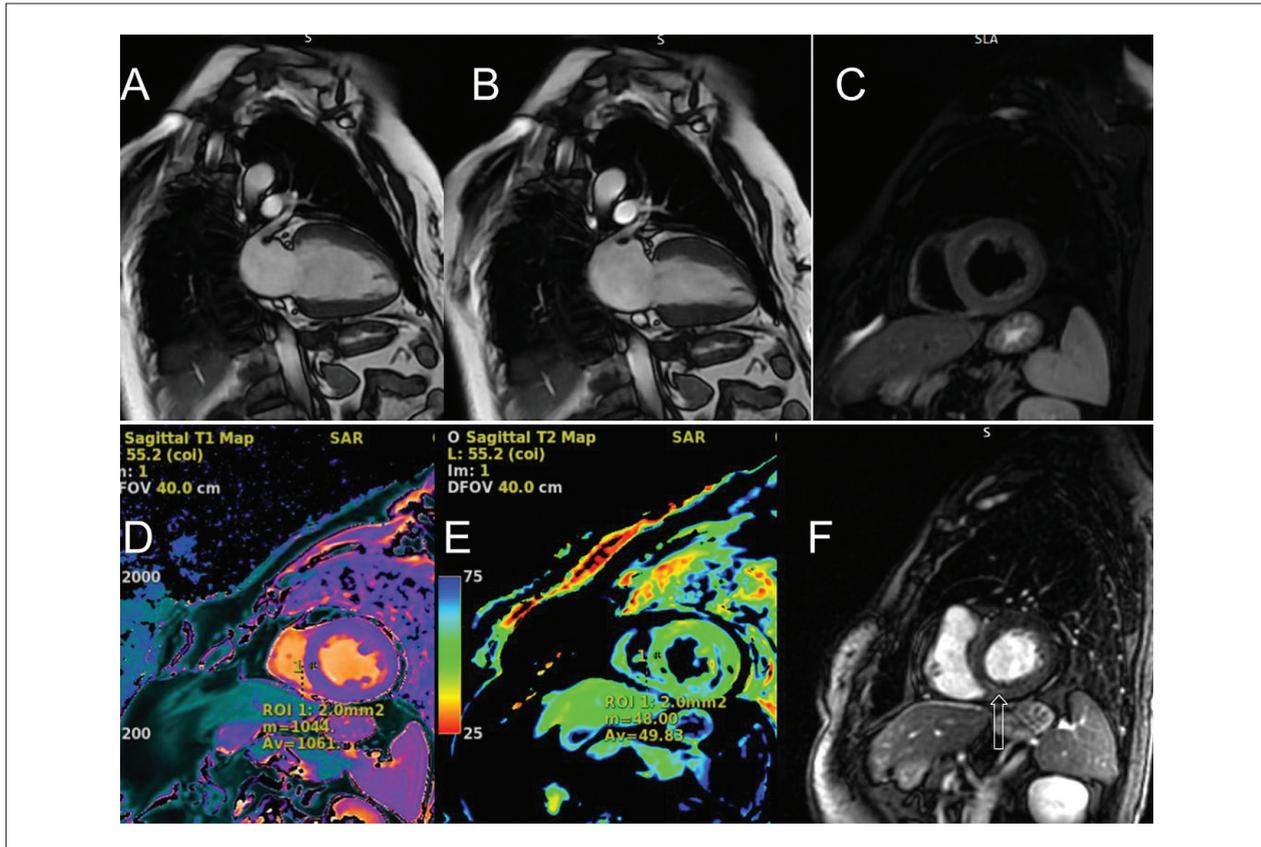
cardiac-MRI. Panels A and B show diastole and systole, respectively, in a two-chamber projection (FFPP). Panel C displays a T2-enhanced sequence. Panels D and E show the T1 and T2 mapping, respectively. Panel F displays a late gadolinium enhancement sequence (PSIR); the arrow indicates the site of enhancement.
